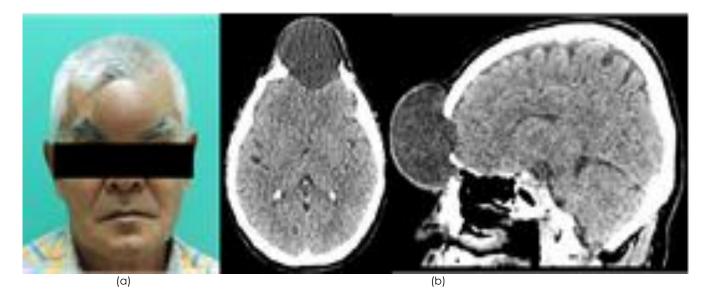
(a) Huge swelling on the patient's forehead and (b) CT data of the patient showing the lesion
